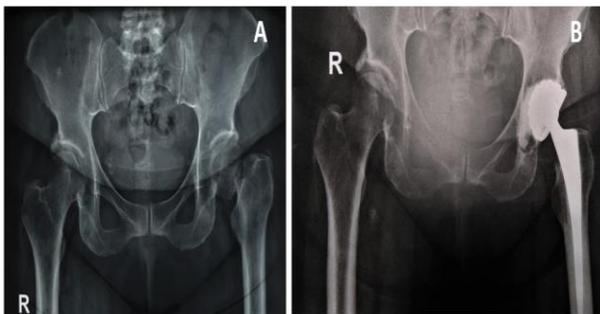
(1A): Pre-operative X-Ray of a 65 years Female, Hypertensive, Stroke, Hemiparesis had Fracture neck of left Femur with Osteoarthritic hip (1B): Post-operative X-Ray of the patient after Cemented Dual Mobility THA
